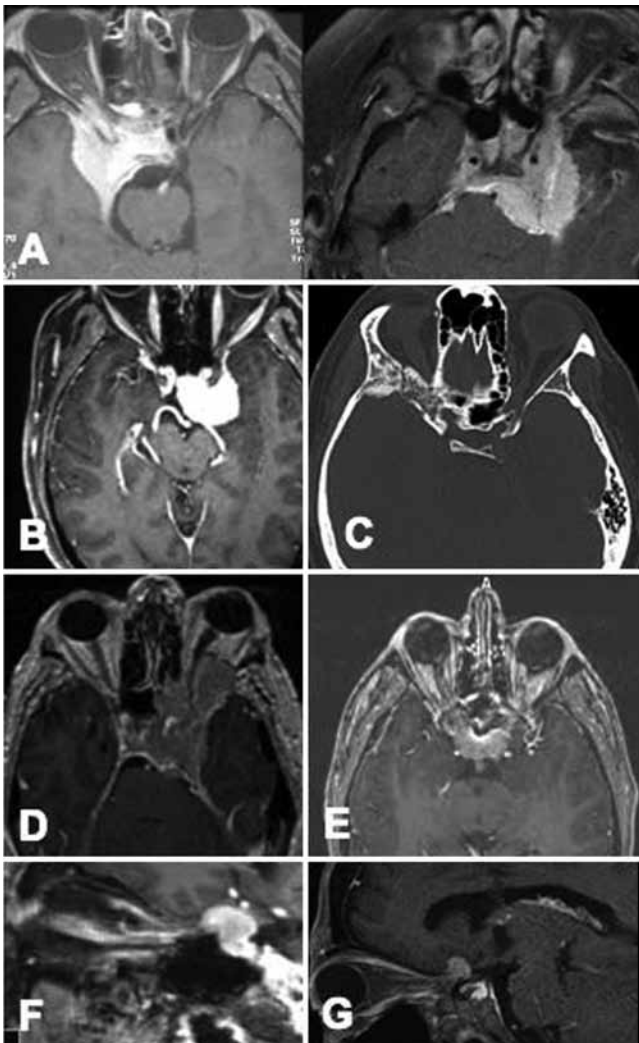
Preoperative neuroimages showing optic canal involvement by different tumors. A: Axial MR images of 2 examples of sphenopetroclival meningioma with involvement of the optic canal. B: Axial MR image of a clinoidal meningioma involving the optic canal both medial and lateral to the optic nerve. C: Axial CT scan of a right sphenoid wing meningioma with bony involvement of the right optic canal. D: Axial MR image of a cavernous sinus meningioma extending into the orbit along the optic canal and superior orbital fissure. E: Axial MR image of a tuberculum sellae meningioma with bilateral involvement of the canal. F: Oblique MR image demonstrating a tuberculum sellae meningioma with extension into the canal. G: Oblique MR image of a recurrent clinoidal meningioma involving the optic canal.
